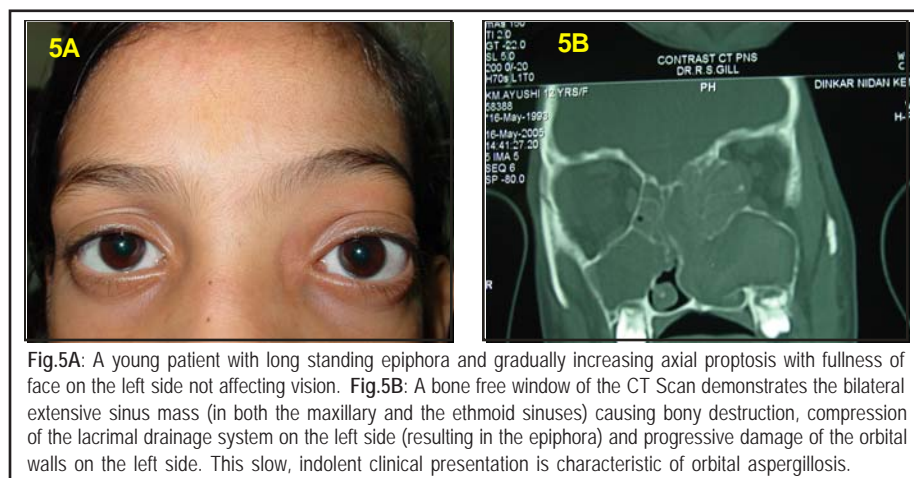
A young patient with long standing epiphora and gradually increasing axial proptosis with fullness of face on the left side not affecting vision. Fig.5B: A bone free window of the CT Scan demonstrates the bilateral extensive sinus mass (in both the maxillary and the ethmoid sinuses) causing bony destruction, compression of the lacrimal drainage system on the left side (resulting in the epiphora) and progressive damage of the orbital walls on the left side. This slow, indolent clinical presentation is characteristic of orbital aspergillosis.
